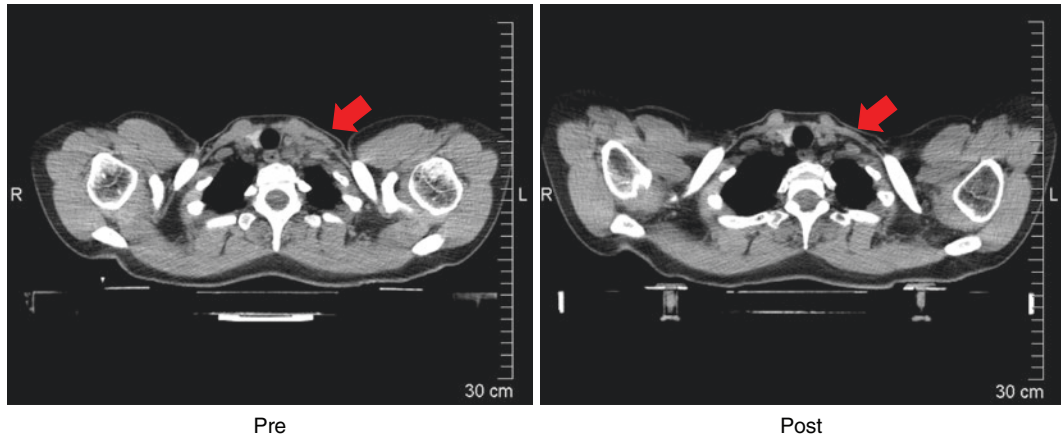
CT imaging in RT position of a locoregionally advanced breast cancer patient pre (left) and post (right) systemic therapy. The initially pathological lymph nodes
